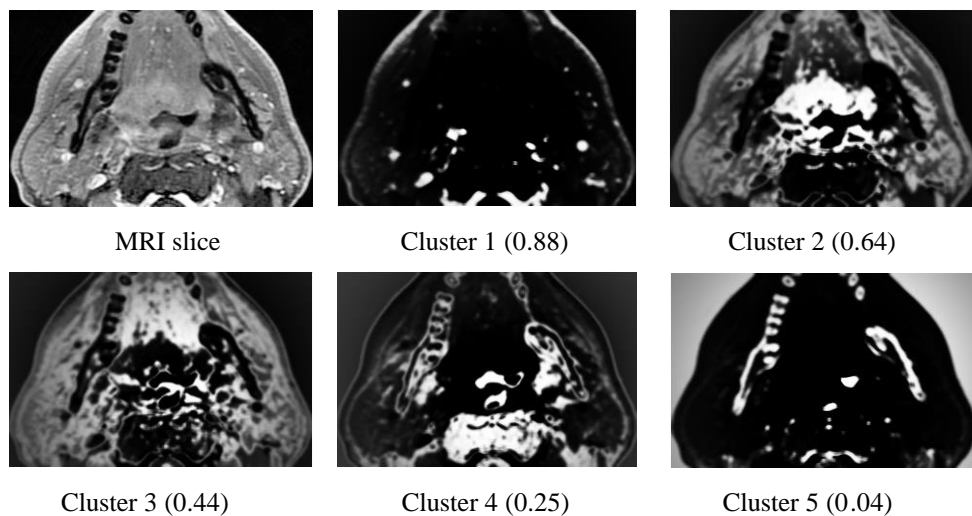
Five clusters (with cluster centres) of MRI slice with visible tumour in Cluster 2. Different tissue types are included in different clusters based on grey-level values.
